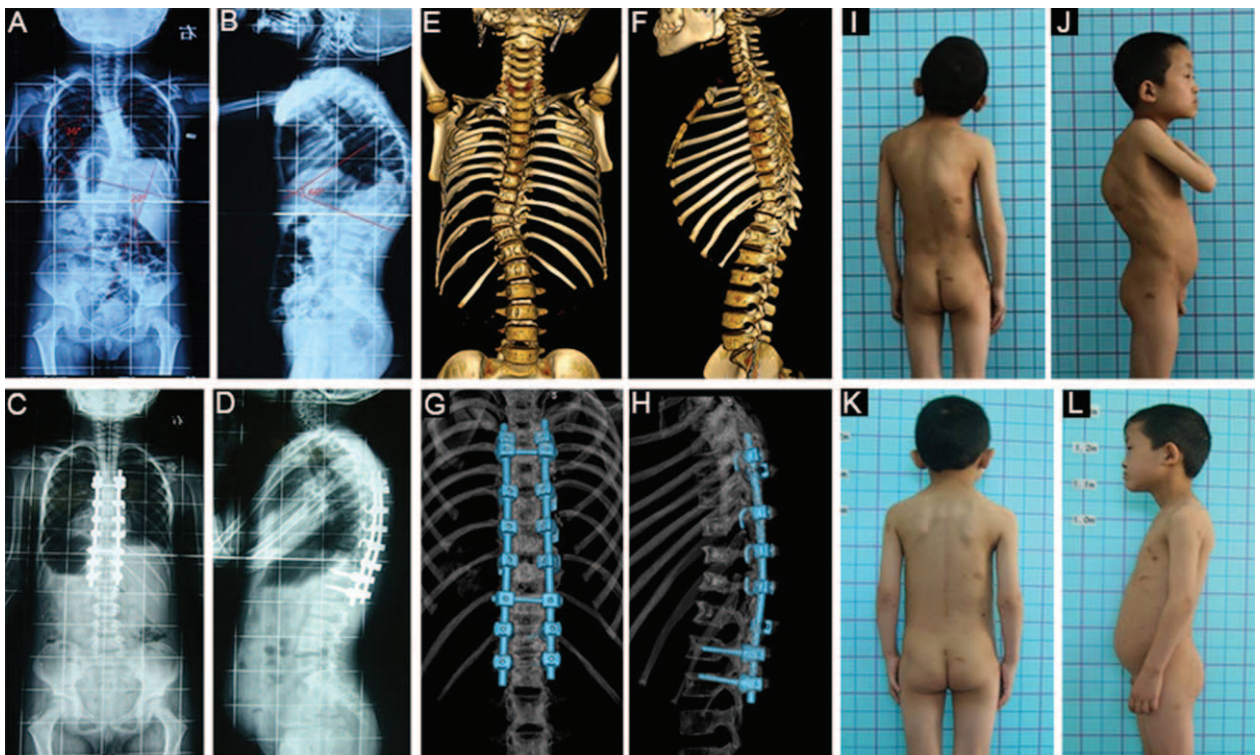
A 9-year-old male with a dystrophic curve preoperative and follow-up AP X-rays (A) and 3D-CT (E) revealing a 36° scoliosis corrected down to 11° (C and G). Preoperative and follow-up lateral X-rays (B) and 3D-CT (F) revealing a 60° thoracic hypokyphosis corrected to 18° (D and H). Preoperative (I and J) and 2-year follow-up (K and L) photographs.
